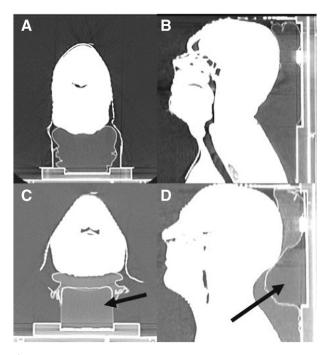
(A) Transversal view and (B) sagittal view of a cone beam computed tomography scan visualizing the standard Vac Lok vacuum cushion. (C) Transversal view and (D) sagittal view of the modified Vac Lok with part of the standard Posifix headrest indicated by the arrows positioned underneath for the correct head position.
